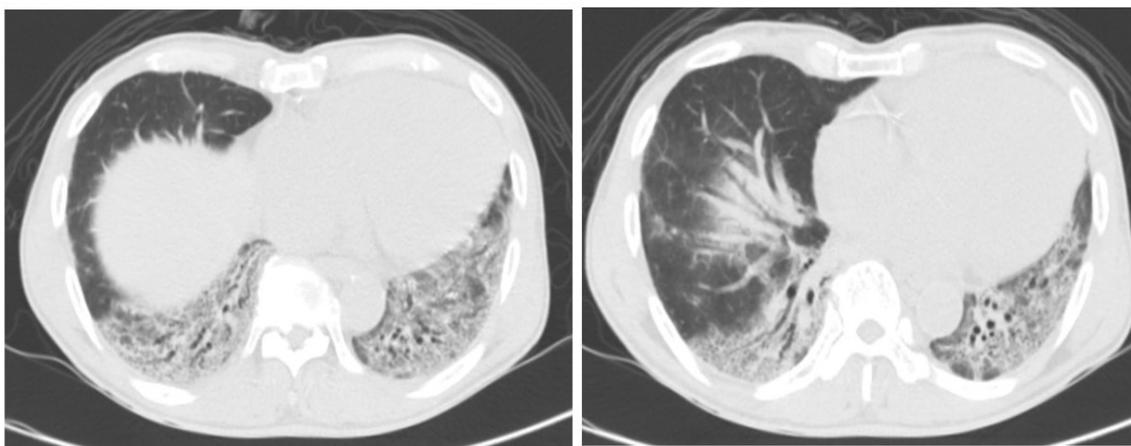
Axial chest CT demonstrates a pattern suggestive of nonspecific interstitial pneumonia (NSIP) in participant No.5—a 66-year-old male with history of exposure to inorganic dust (suspected silica and asbestos) while working in construction for about 20 years.
